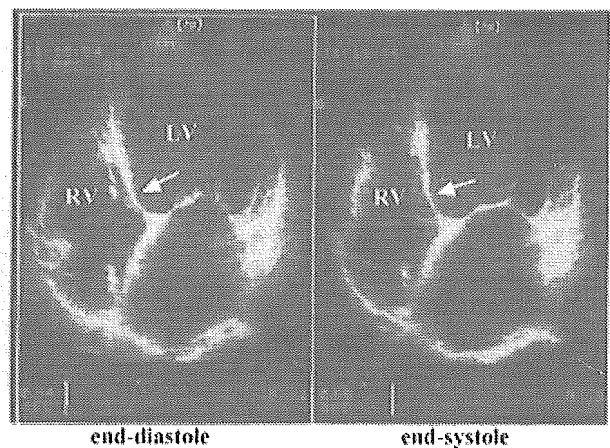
Ultrasonic echocardiogram before left ventriculoplasty from four-chamber view, showing thinning of basal portion of interventricular septum (arrows). (LV: left ventricle, RV: right ventricle)
